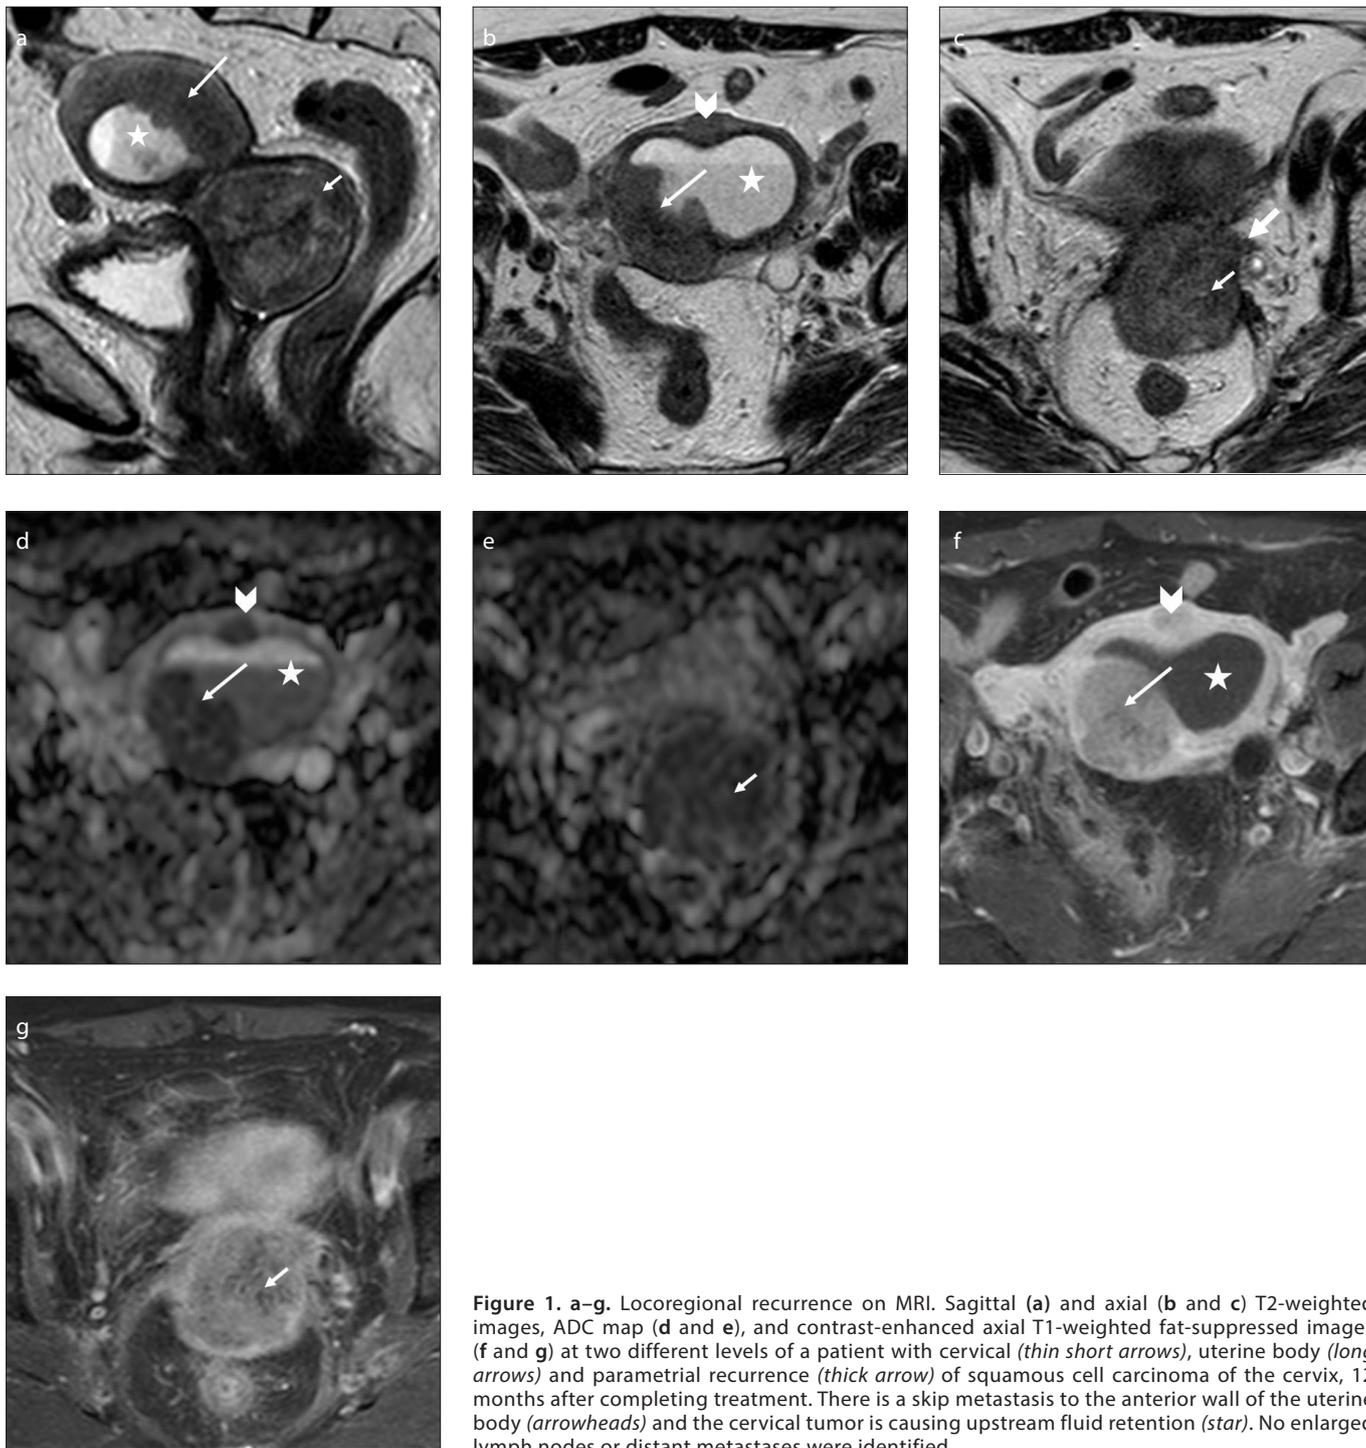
a–g. Locoregional recurrence on MRI. Sagittal (a) and axial (b and c) T2-weighted images, ADC map (d and e), and contrast-enhanced axial T1-weighted fat-suppressed images (f and g) at two different levels of a patient with cervical (thin short arrows), uterine body (long arrows) and parametrial recurrence (thick arrow) of squamous cell carcinoma of the cervix, 12 months after completing treatment. There is a skip metastasis to the anterior wall of the uterine body (arrowheads) and the cervical tumor is causing upstream fluid retention (star). No enlarged lymph nodes or distant metastases were identified.
